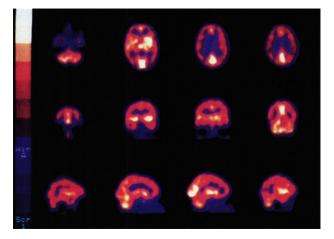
Normal volunteer demonstrating normal HMPAO SPECT images.
